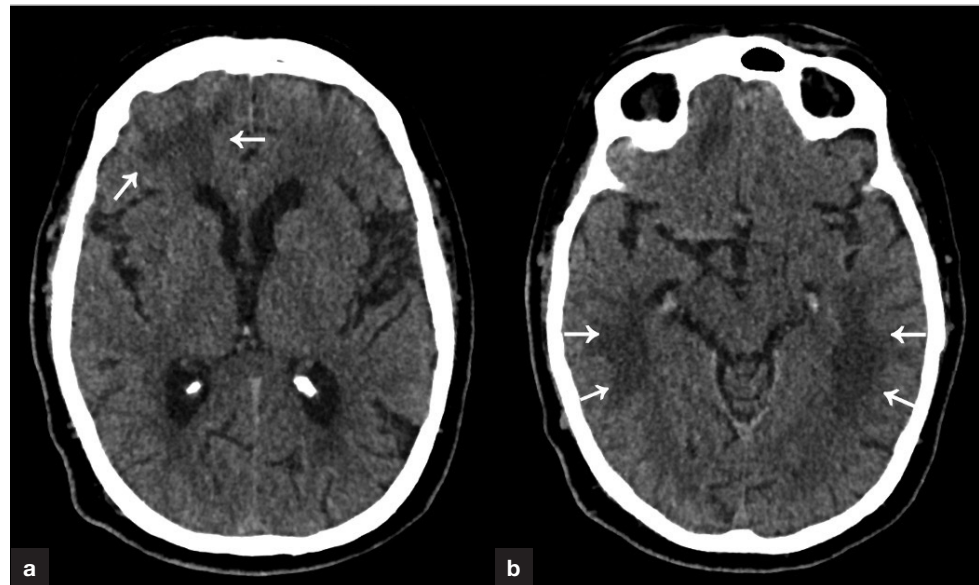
Axial unenhanced computed tomography images of the brain demonstrate (a) multiple large areas of hypodensity in the juxtacortical and deep white matter of the right frontal lobe and both temporal lobes (arrows), (b) in a distribution atypical for small vessel disease. No discrete mass lesion or pathological enhancement was evident on post-contrast imaging (not shown).
